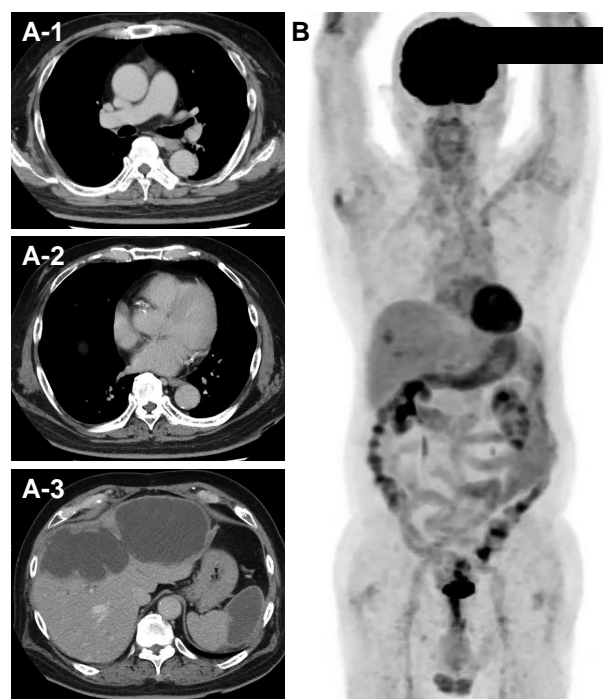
(A) Contrast-enhanced computed tomography on Day 45 showed that the thrombi in pulmonary artery and descending aorta had disappeared; however, a low density area remained in the liver and spleen. (B) A fluorodeoxyglucose-positron emission tomography computed tomography 6 months after multi-disciplinary therapy showed that the hyperaccumulation in the lymph nodes had disappeared.
